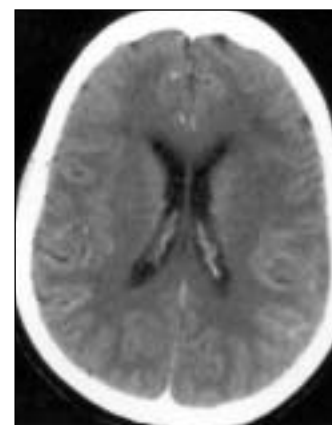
Plain and contrast CT scan of the brain done on 07/11/2003 shows no significant abnormality
